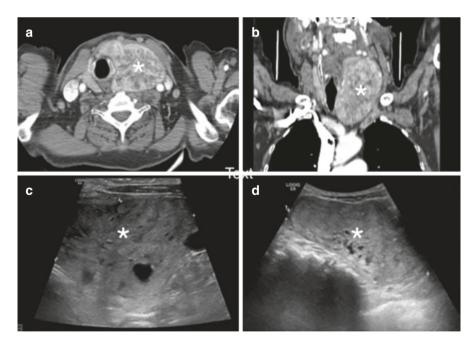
Nodular goiter. The thyroid gland is enlarged (asterisks) and a big left lobe nodule showing mediastinal extension is shown on axial (a) and coronal (b) CT scans, as well as axial (c) and longitudinal (d) US scans
